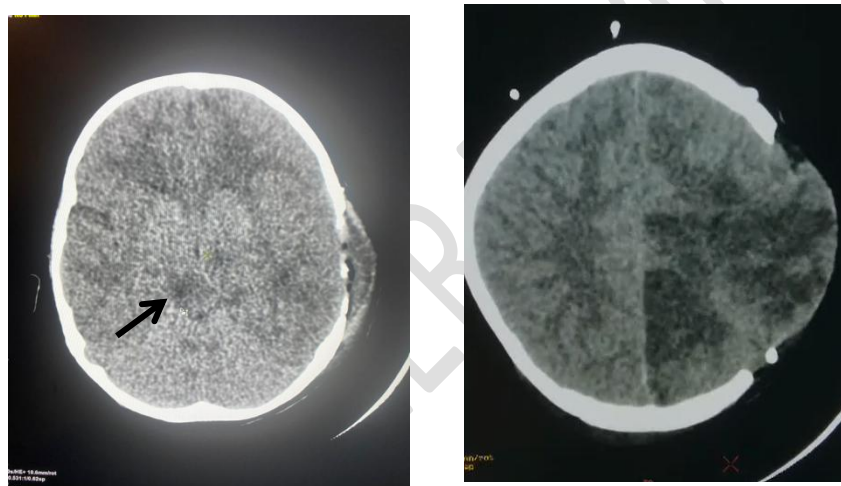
showed post operative CT scan. On right side noted focal area of hypodensity in right crus cerebri in midbrain. On left sided showed hypodensities over left anteromedial temporal lobe and occipital lobe representing infarcts.
